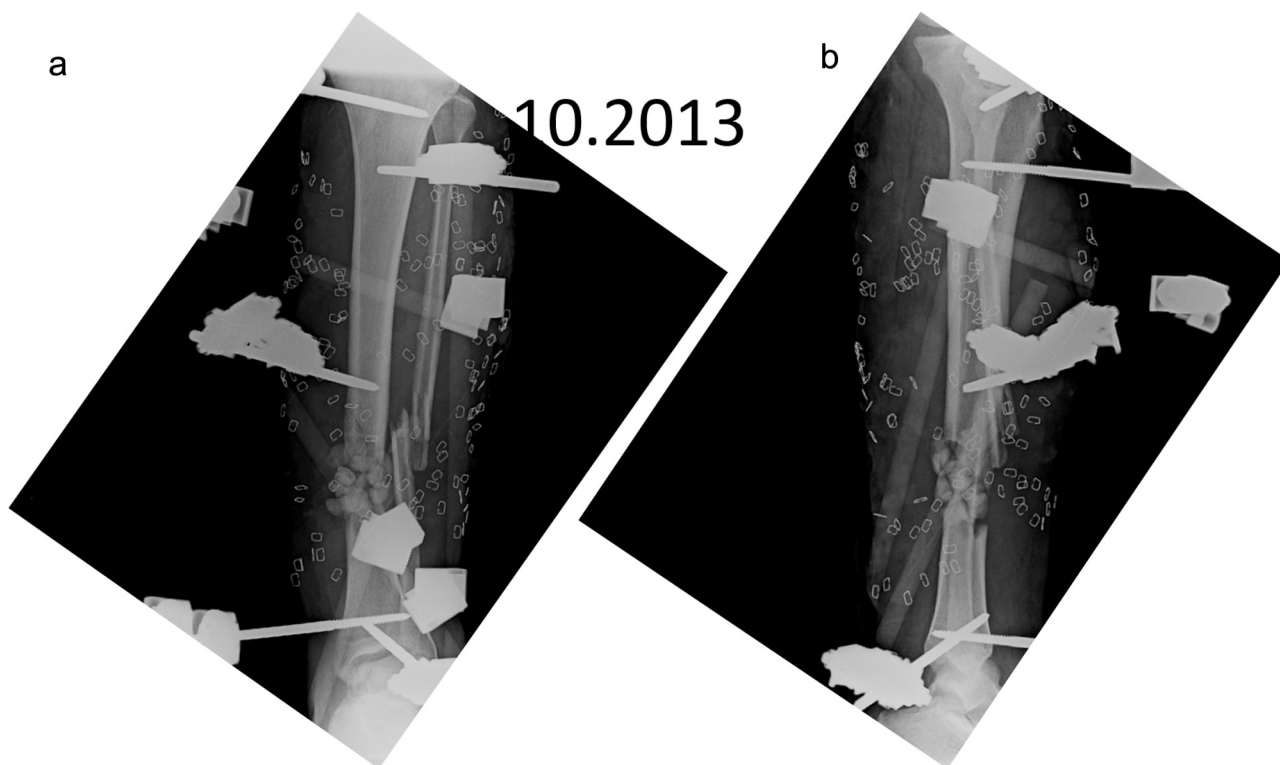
a and b postoperative anteroposterior and lateral radiographies of the crus.
